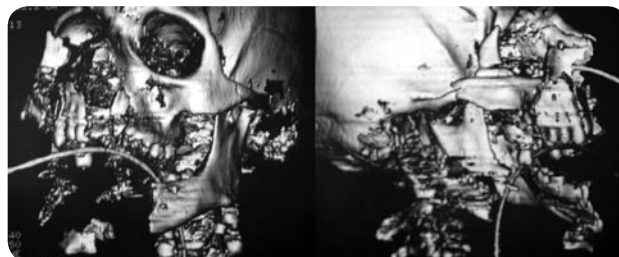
Radiograph showing significant loss of tissue.
